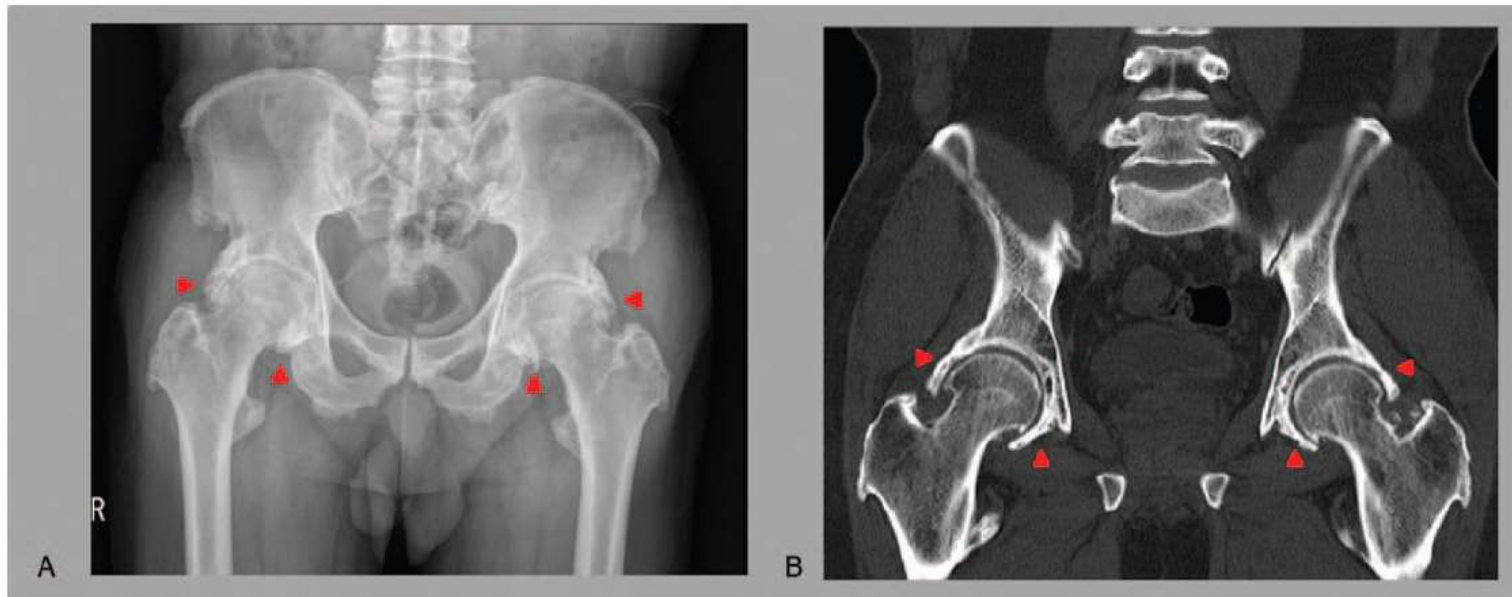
On anteroposterior pelvic X-ray (A) and coronal pelvic computed tomography (B), severe and diffuse hyperostosis was observed around the bilateral hip joints (red arrow heads).
